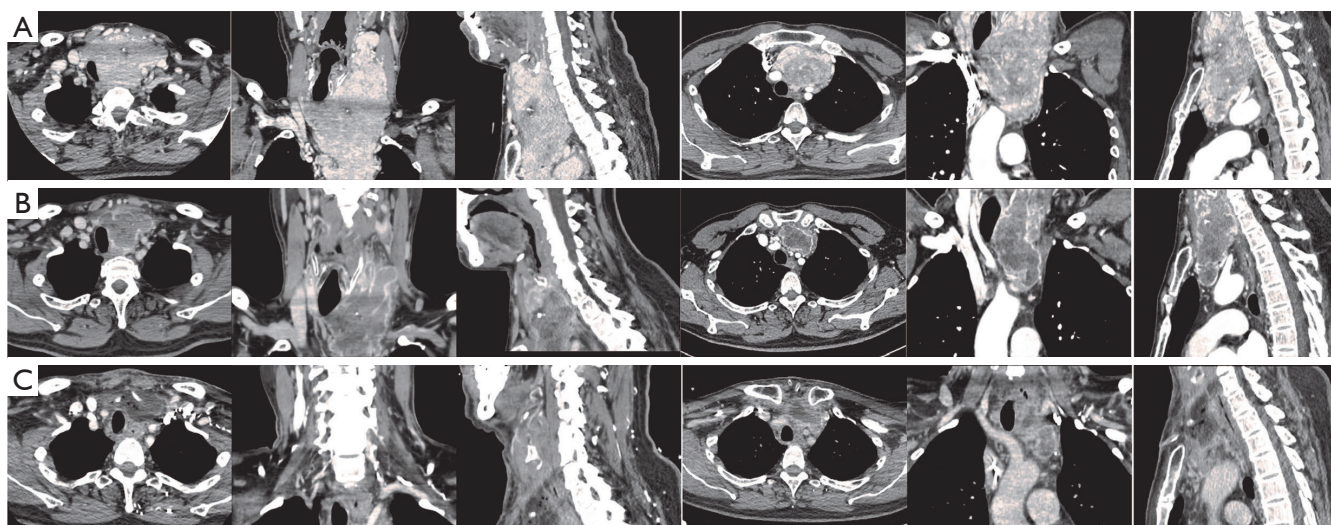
Contrast-enhanced CT images at different times. (A) Initial visit; (B) after 6 cycles of therapy with anlotinib; (C) 6 days after operation. CT, computed tomography.
